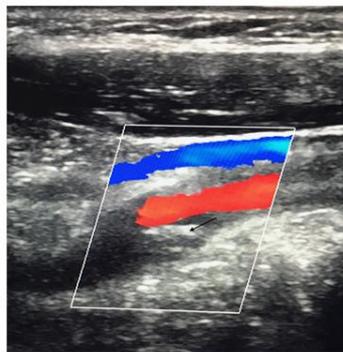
Color duplex ultrasound demonstrated a diaphragm (black arrow) in the left CCA
